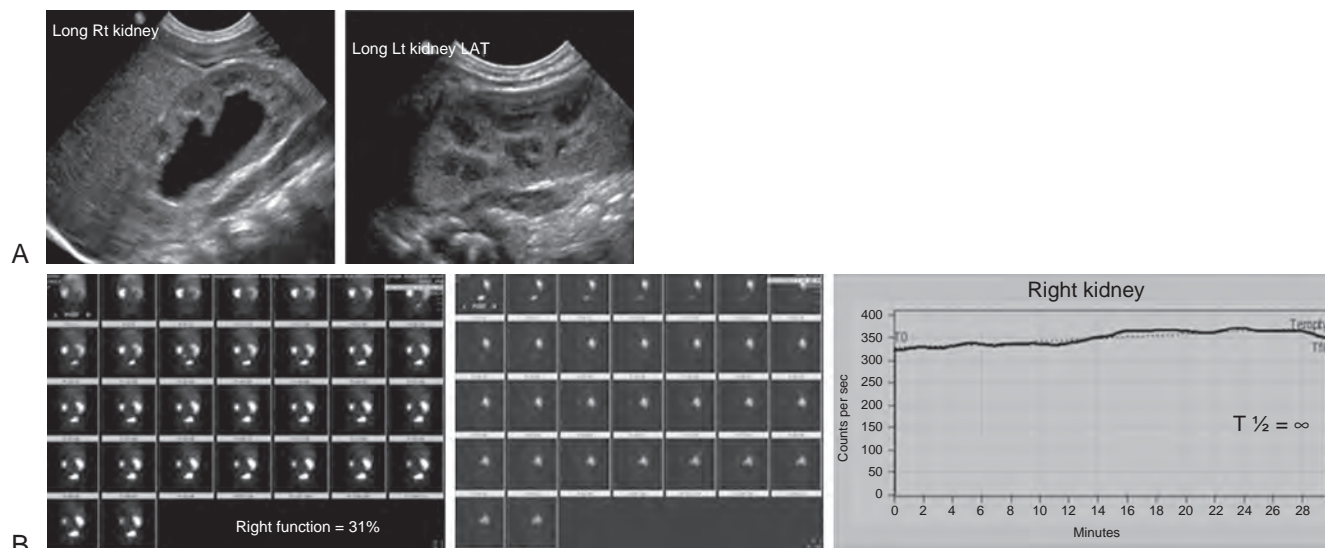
A, Renal sonogram demonstrating grade 3 hydronephrosis (mostly intrarenal dilation) without hydroureter. The left kidney is normal. B, ^{99m}Tc -Mercaptoacetyltryglycine furosemide renal scan showing high-grade ureteropelvic junction obstruction with reduced renal function from the right kidney (31%). The diuresis curve demonstrates no drainage and instead reflects continuous accumulation of tracer in the right collecting system.
